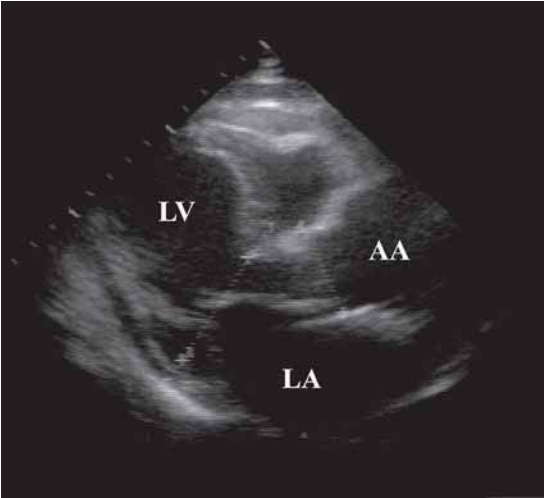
Stop frame from two-dimensional echocardiogram from a patient taken in the parasternal long axis showing dilated aneurysmal ascending aorta (AA) just above the aortic valve. Note that the orientation of the AA is such that it is at a 90° angle to the longitudinal axis of the left ventricle (LV).
